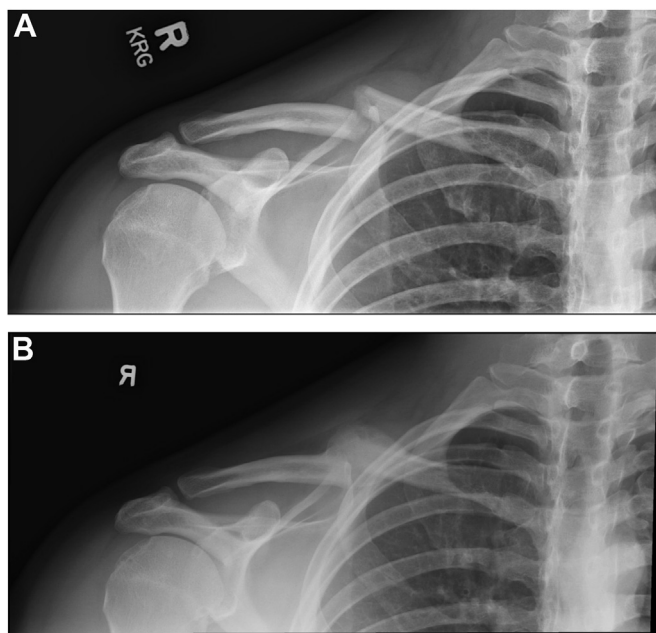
(A) Initial injury plain radiographs depicting a displaced midshaft clavicle fracture and (B) subsequent malunion.
